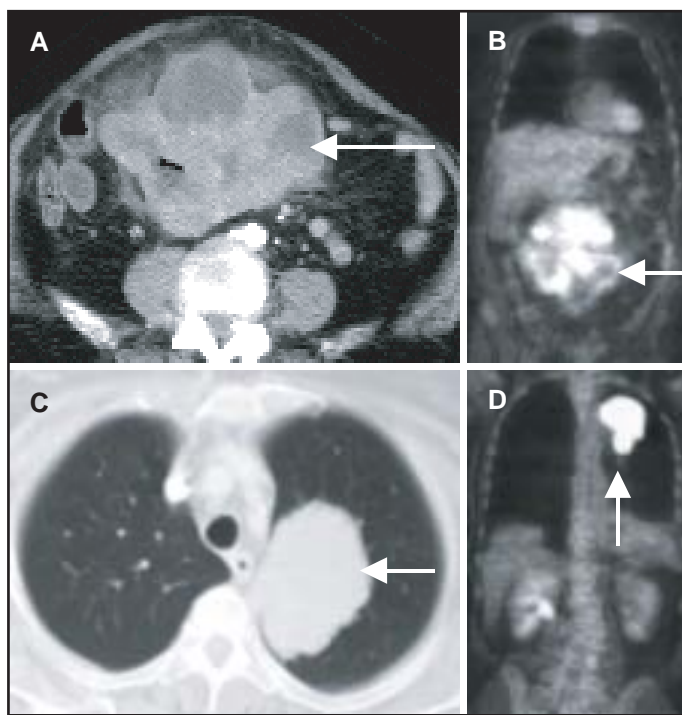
Small bowel GIST. (A) CT of the abdomen shows a large heterogeneous exophytic mass with central areas of low density and gas (arrow). (B) Coronal CT-PET shows uptake of [¹⁸F]FDG in the abdominal mass (arrow). (C) CT of the thorax shows a large left upper lobe lung metastasis (arrow). (D) Coronal CT-PET shows uptake of [¹⁸F]FDG in the left lung metastasis (arrow).
